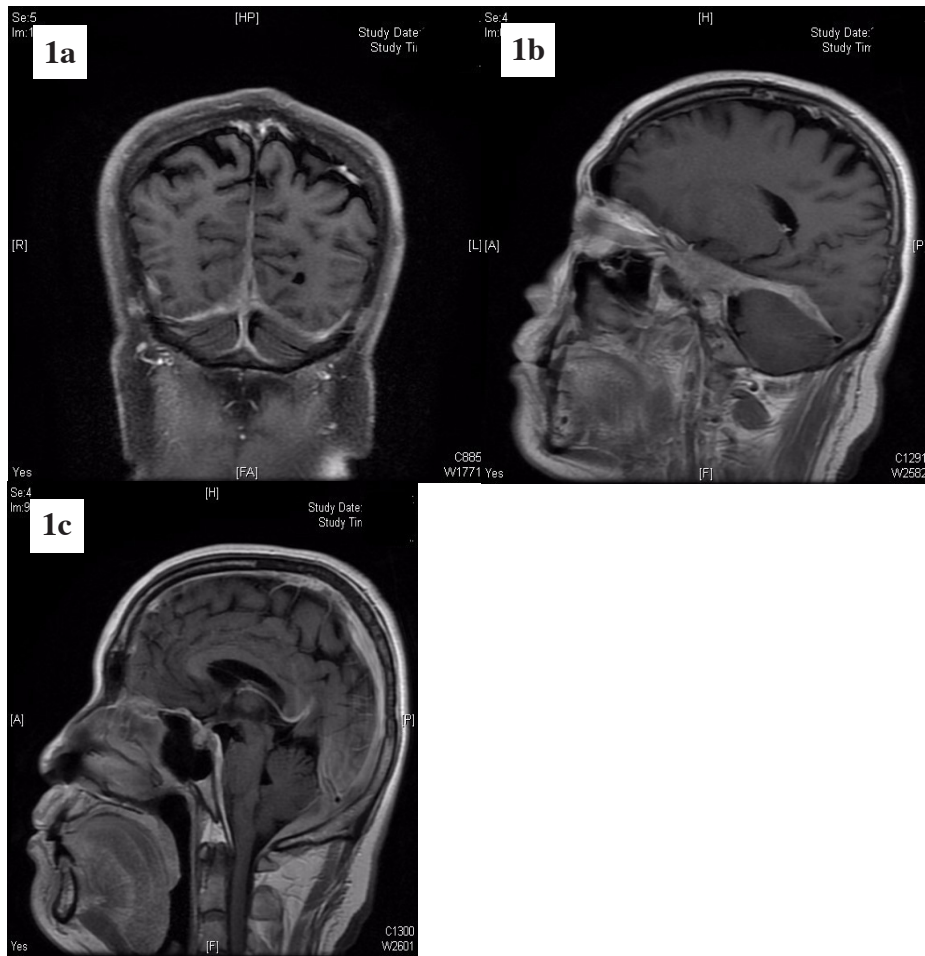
Gadolinium-enhanced T1-weighted MR imaging of Case 8, showing diffuse and wide thickening of the tentorium and falx cerebri in the coronal (1a) and sagittal views (1b and 1c).
